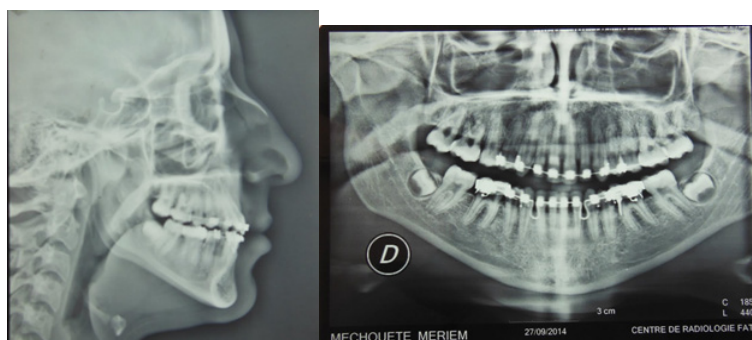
Lateral Cephalometric and Panoramic X-ray at the End of Treatment.
